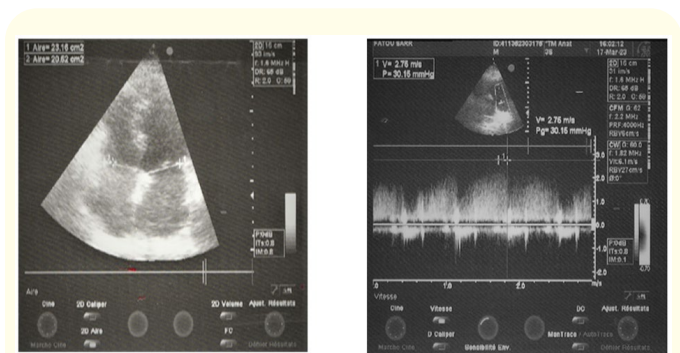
Transthoracic cardiac Doppler.
